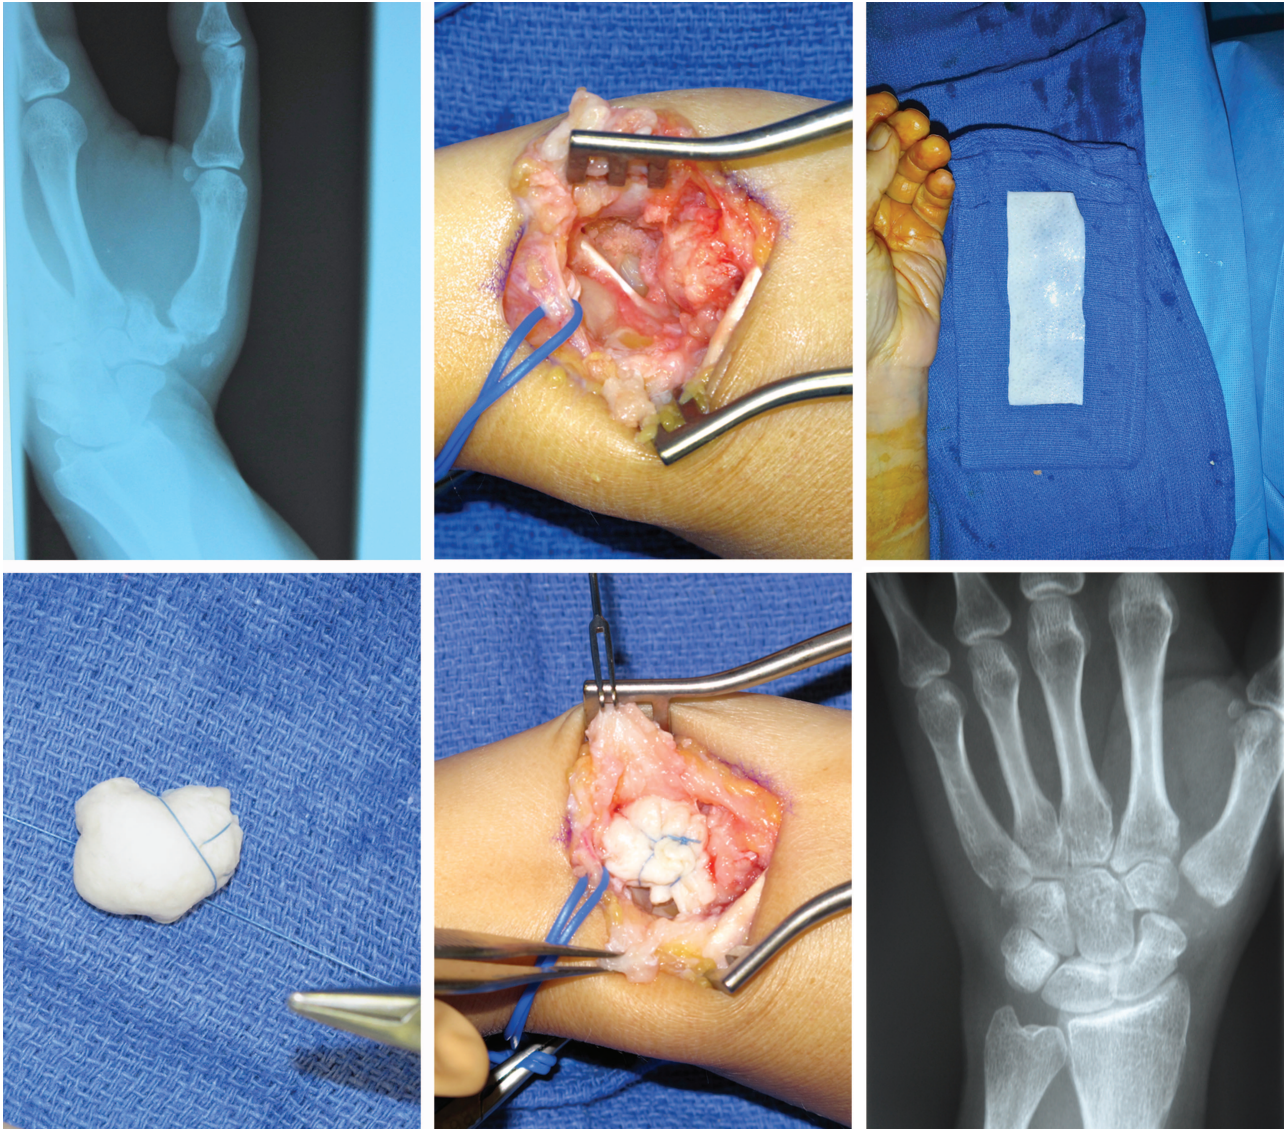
First carpometacarpal joint arthritis: trapeziectomy with acellular dermal matrix interposition arthroplasty. (Above, left) Preoperative radiograph showing stage IV arthritis. (Above, center) Complete trapeziectomy. (Above, right) acellular dermal matrix allograft (3 × 7 cm). (Below, left and below, center) acellular dermal matrix interposition arthroplasty. (Below, right) Postoperative radiograph at 1 month.
